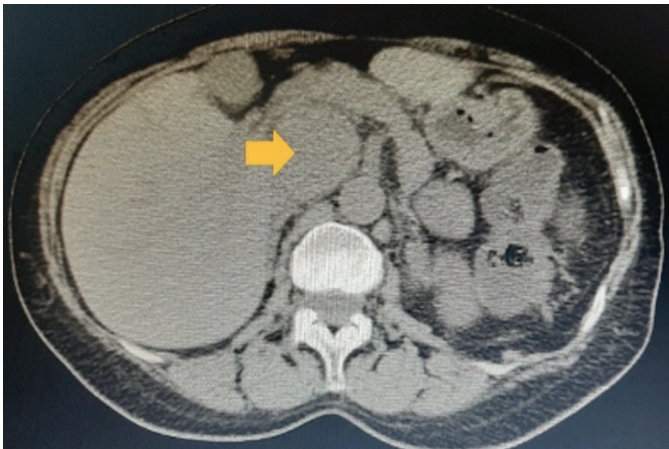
Plain abdominal CT scan showing a well-defined, round focus at the retropancreatic area (arrow) with minimal compression of the pancreas and surrounding vessels anterosuperiorly.
